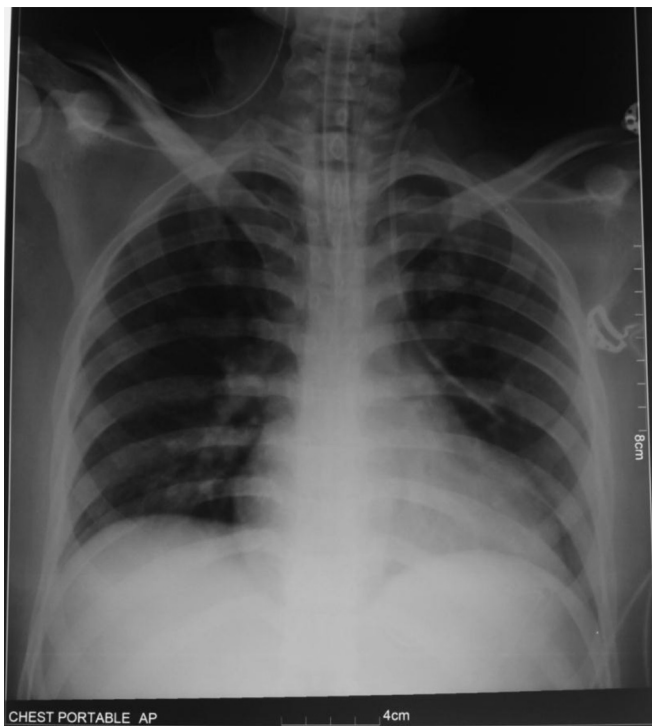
Chest radiograph posterior-anterior view showing malpositioned central venous catheter pointing toward the left pleural cavity and outside pericardial cavity without pleural effusion.
